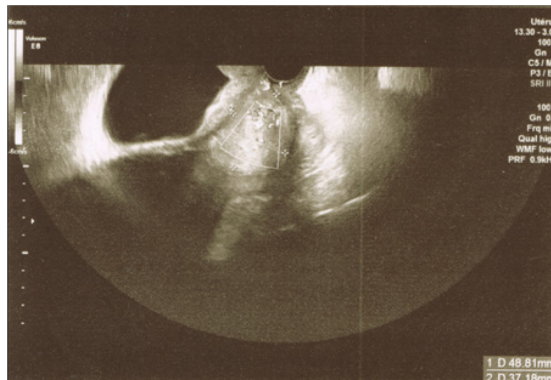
First ultrasound image taken in the Emergency Department
